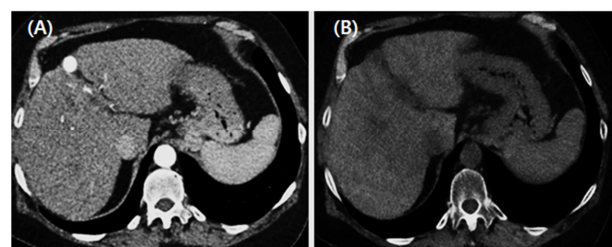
Dual Energy CT image. A: A suspected lesion in the liver 4th area was shown to be enhanced in the arterial phase, raising concerns about tumor recurrence. B: No enhancement of the lesion was confirmed in the virtual
